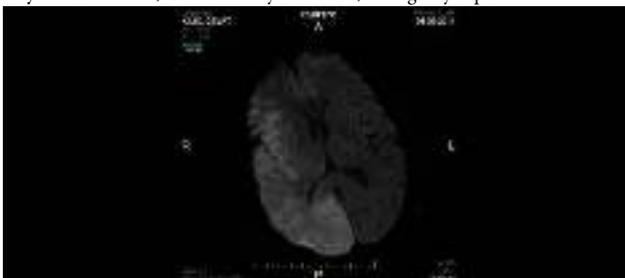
Diffusion weighted MRI
